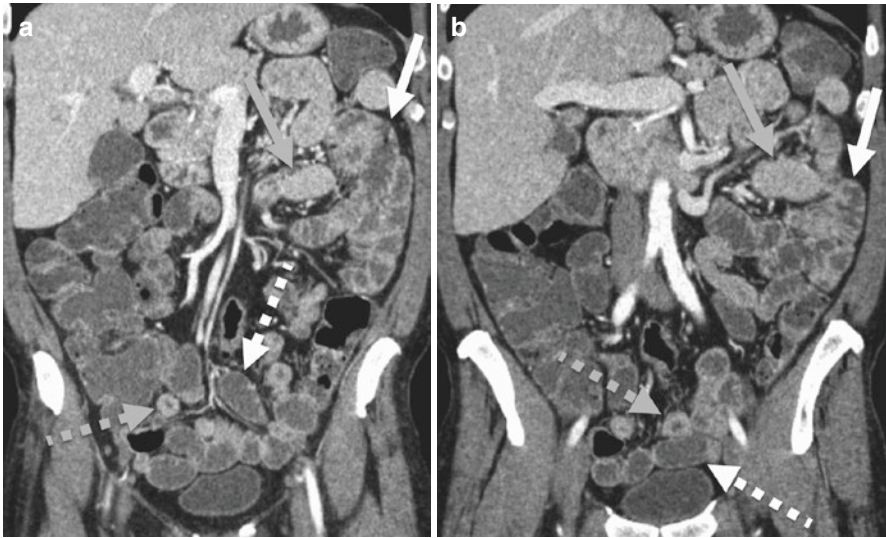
Normal CT enterogram using low-density barium sulfate suspension (a) and (b). Collapsed loops of jejunum (*solid gray arrows*) have higher attenuation than distended loops of jejunum (*solid white arrows*), and collapsed loops of ileum (*dashed gray arrows*) have higher attenuation than distended loops of ileum (*solid dashed arrows*). Also, overall attenuation of the jejunum is greater than the ileum
